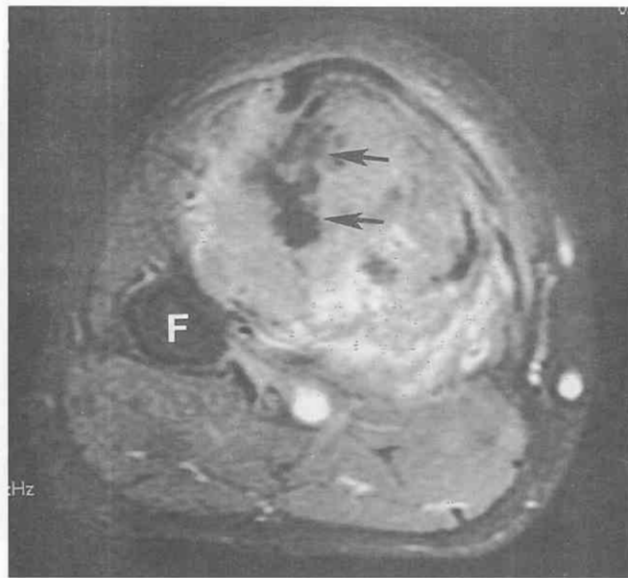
Osteosarcoma in a 15-year-old boy. Postgadolinium axial T1-weighted image (TR = 550 msec, TE = 8 msec) with fat saturation shows enhancing soft tissue of an osteosarcoma replacing the proximal tibial metaphysis. The cortex is largely destroyed. An area of low signal intensity (arrows) represents osteoid formation. F, fibula.
